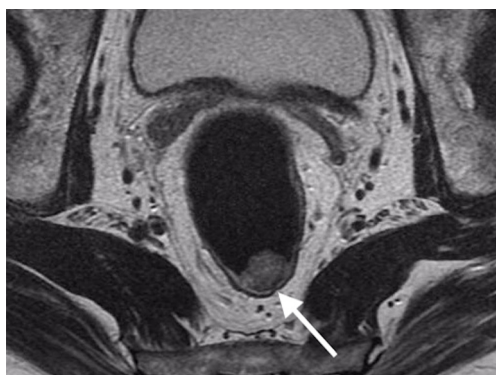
Rectal MRI shows a rectal cancer confined to the submucosa (mrT1 tumour), amenable to primary local resection.
